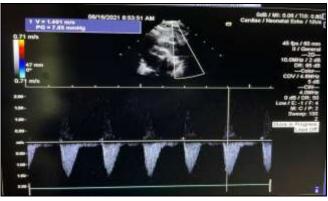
Aortic end of device with CW Doppler Spectral Analysis showing no Coarctation
